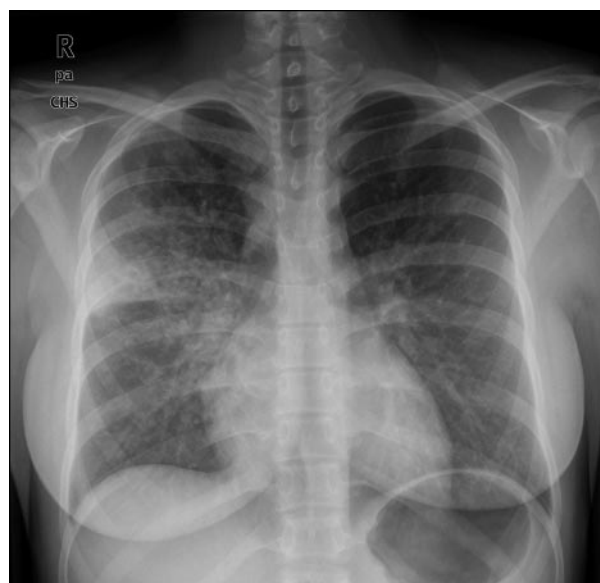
Radiographic findings of *Mycoplasma pneumoniae*: Bilateral reticular/nodular interstitial infiltrates, with more focal patchy alveolar opacity in the right middle lobe, and opacity in the right upper lobe abutting the slightly elevated minor fissure, indicative of subsegmental right upper lobe atelectasis.
